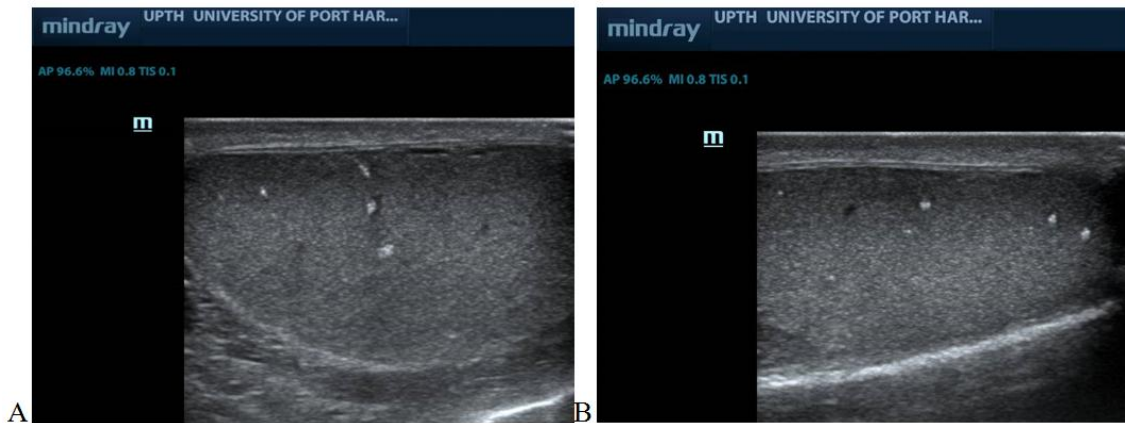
Testicular Microlithiasis. Sonograms showing non-shadowing echogenic foci in the testicular parenchyma
